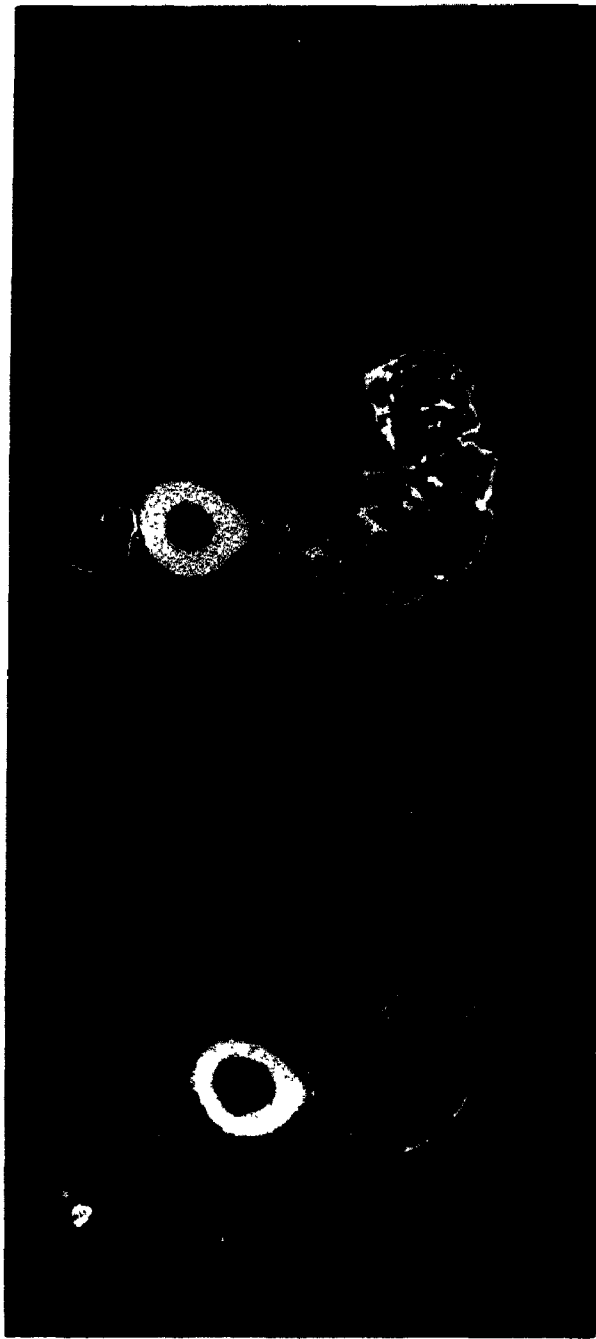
CT scan at greatest girth of hamstring muscles from 20 year old man (left) and 65 year old man (right). Hamstring area is outlined and non-muscle tissue is highlighted.
